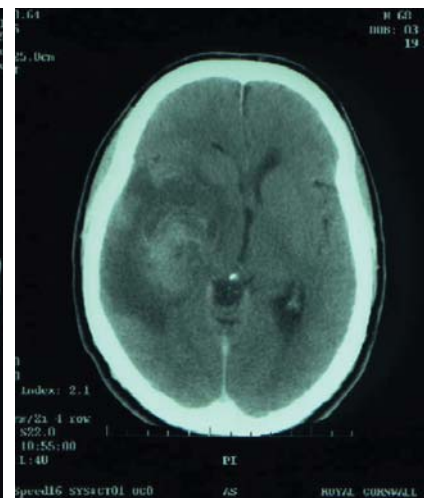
Five weeks later he developed symptoms of raised intracranial pressure. A repeat CT scan revealed a space-occupying lesion, confirmed at biopsy to be a glioblastoma multiforme.
